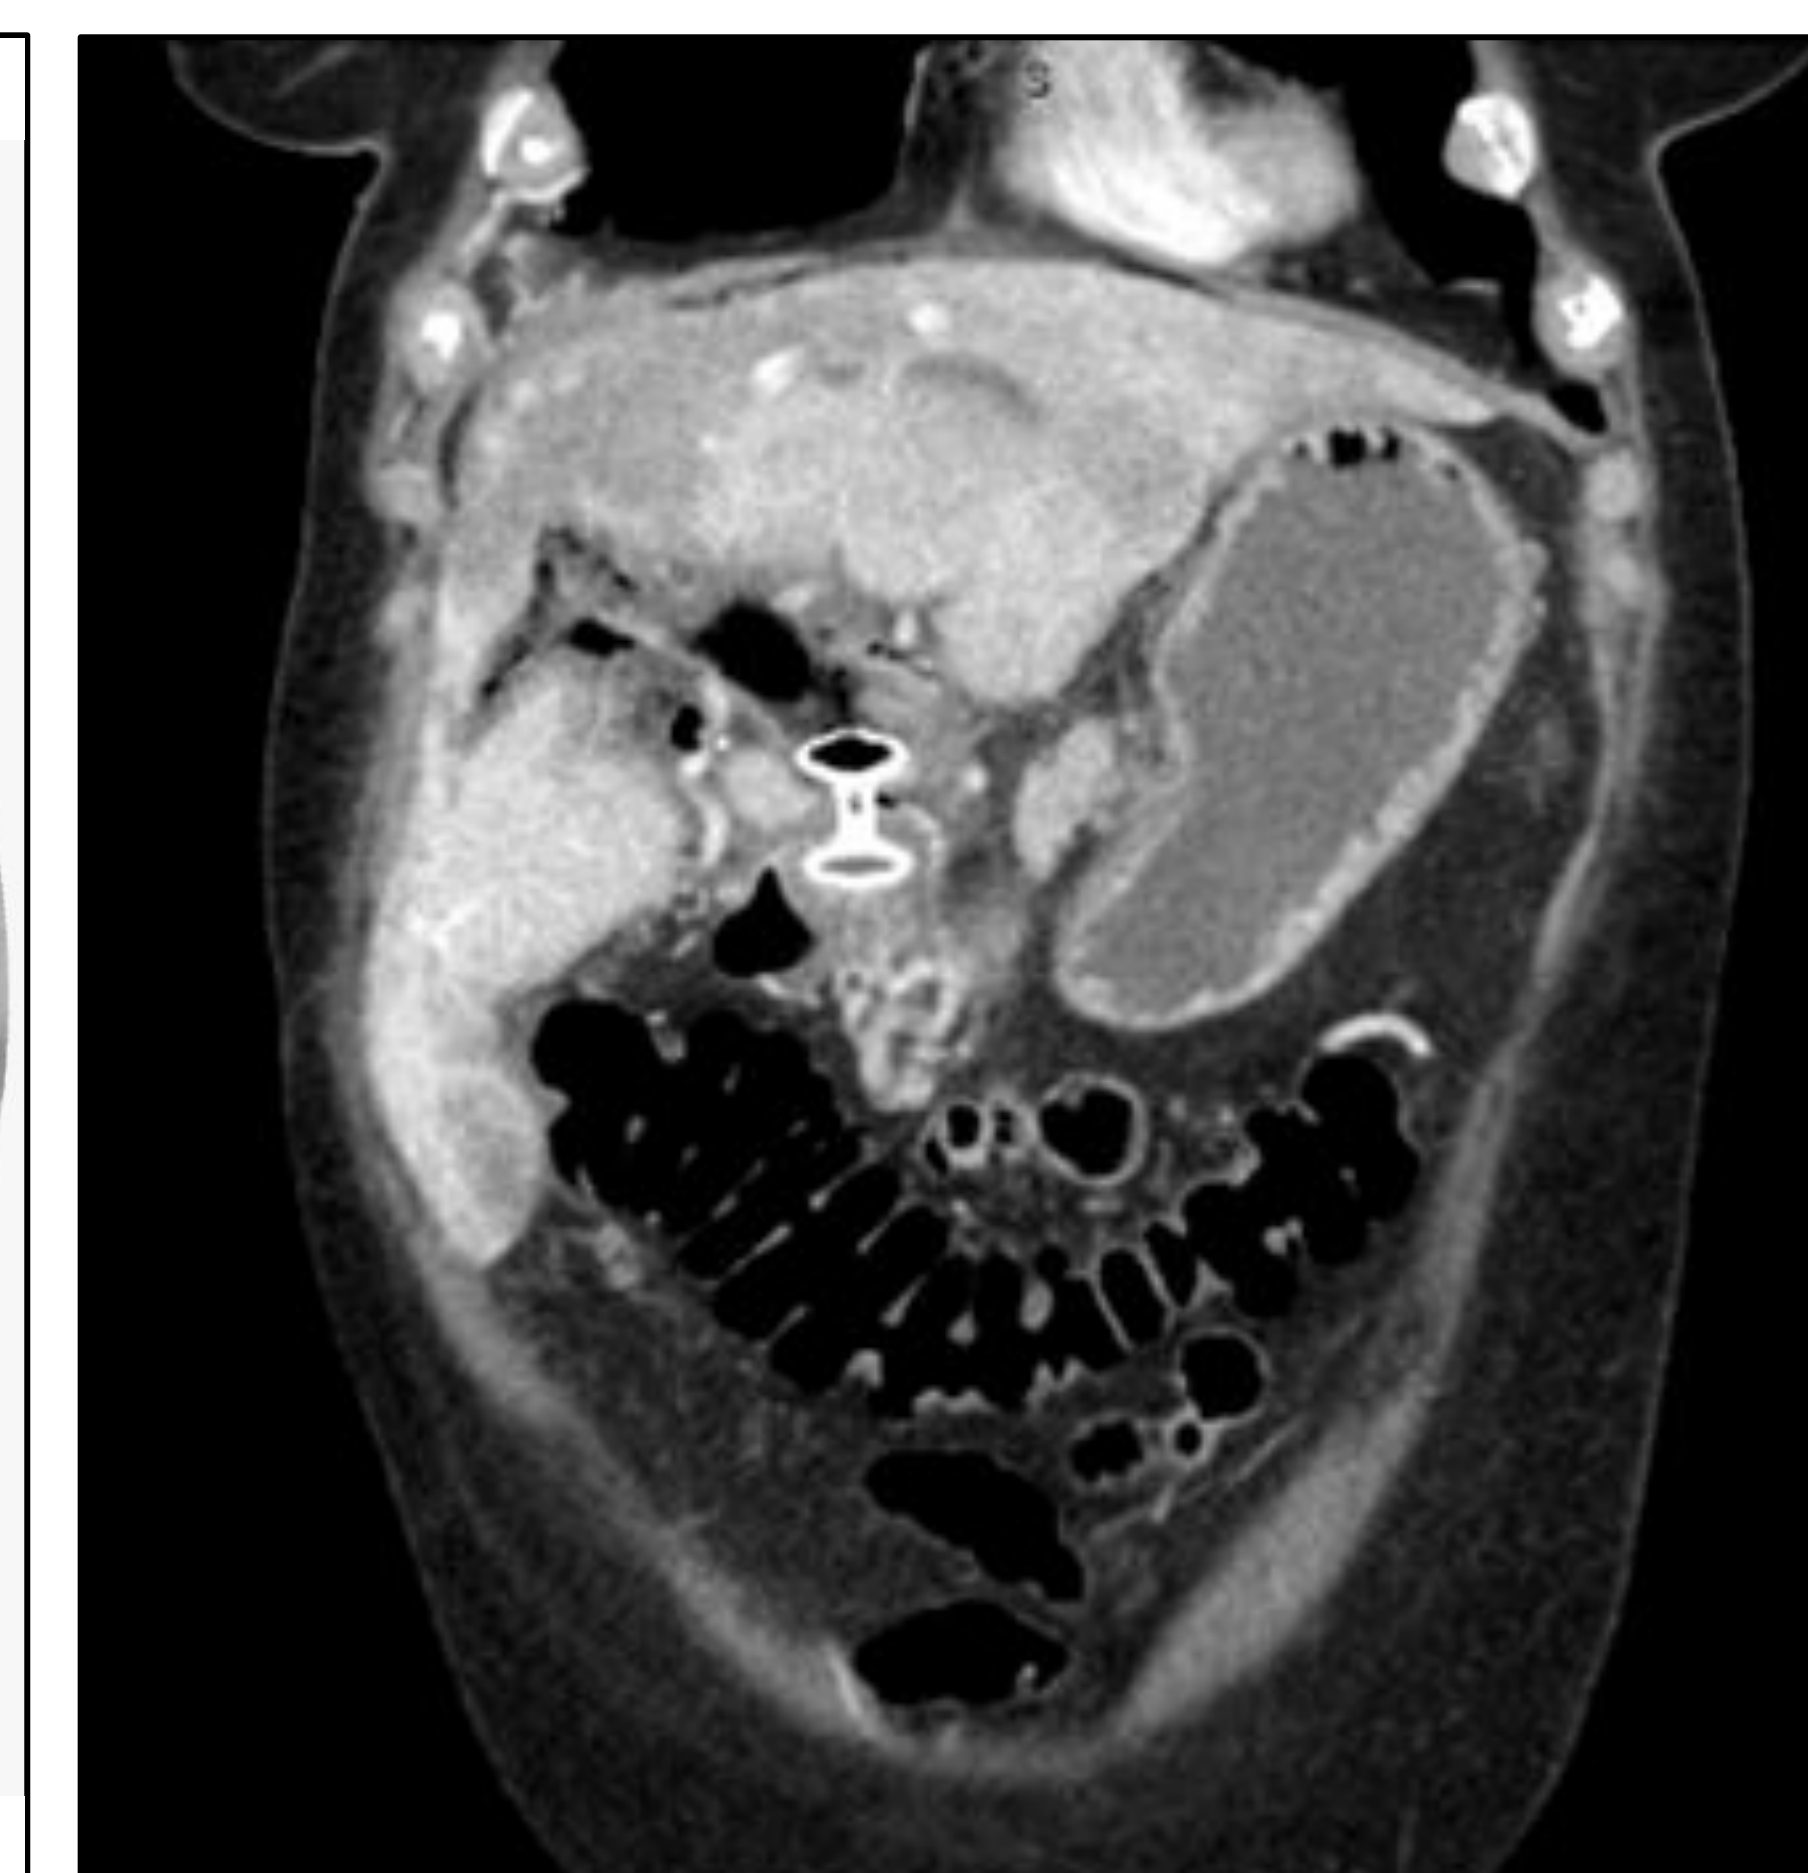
CT coronal view demonstrating LAMS completed via EUS-CD
